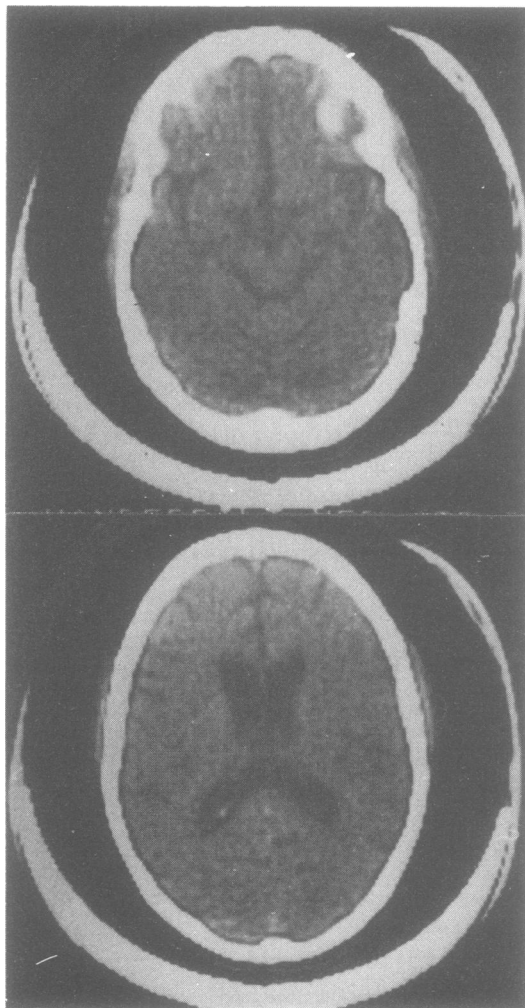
Computed tomographic scan shows cerebellar and cerebral cortical atrophy.
